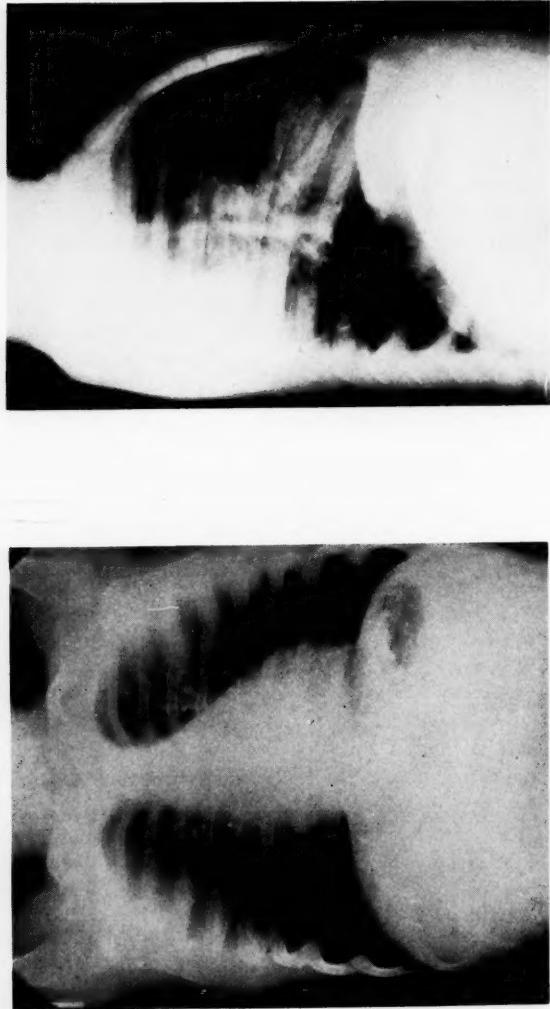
Radiographs of same patient as shown in Fig. 1, following bronchoscopy. Dilatation of the inflammatory and bronchial stenosis and aspiration of the obstructing purulent secretion, which produced the atelectasis, resulted in prompt reeration of the involved portion of the right lower lobe.
